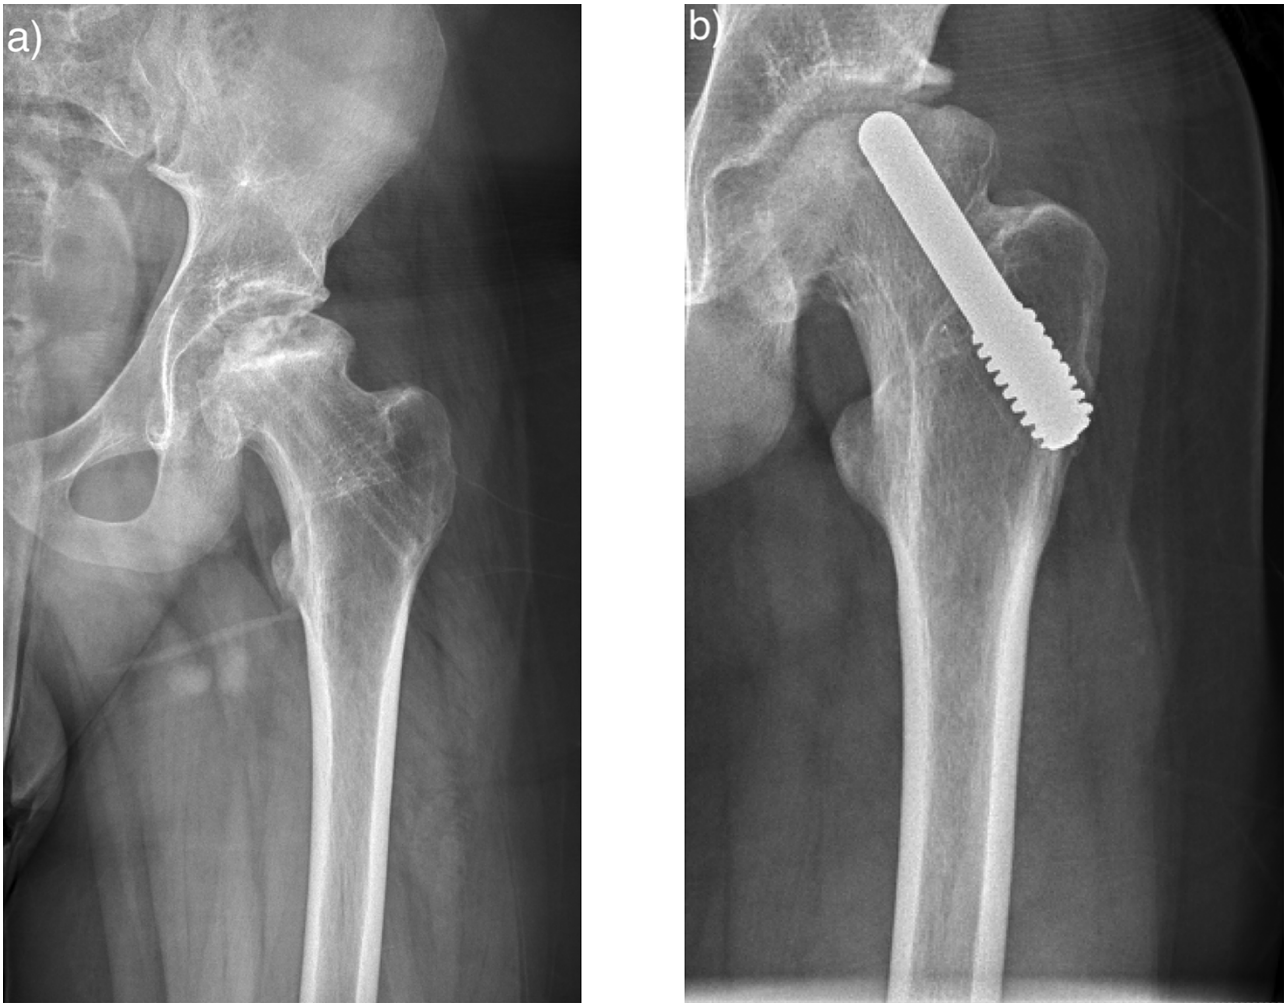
Pre-operative radiograph prior to tantalum rod insertion (a) and post-operative radiograph at 14 months with tantalum rod *in situ* (b).
